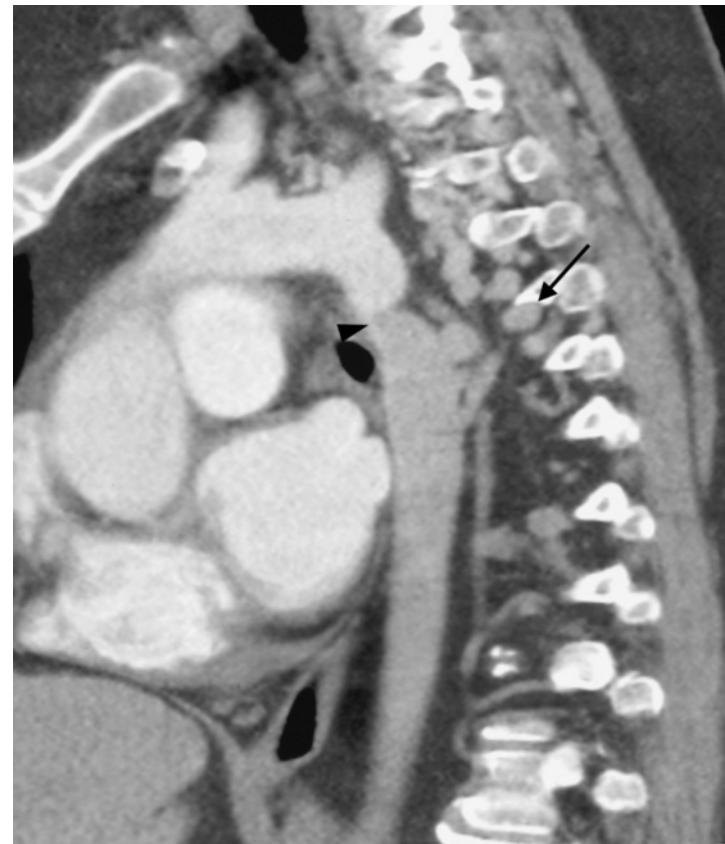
Sagittal CT reconstruction. Ectasia of the intercostal arteries and rib notching (black arrow) are clearly visualized in coarctation of the aorta (black arrowhead).
